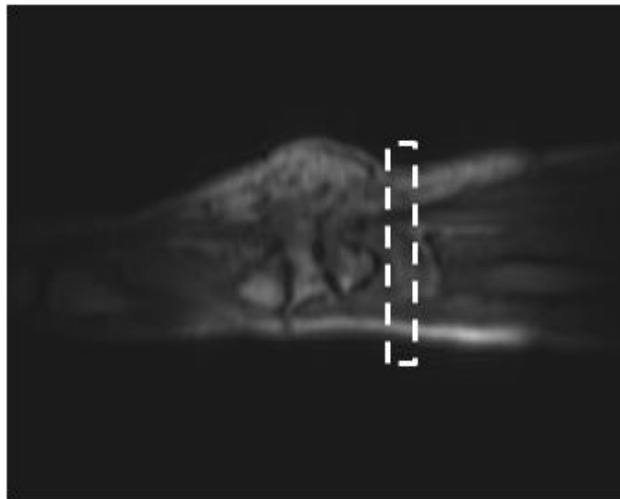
15 A typical MR image shows an axial slice position in the sagittal plane scout image
